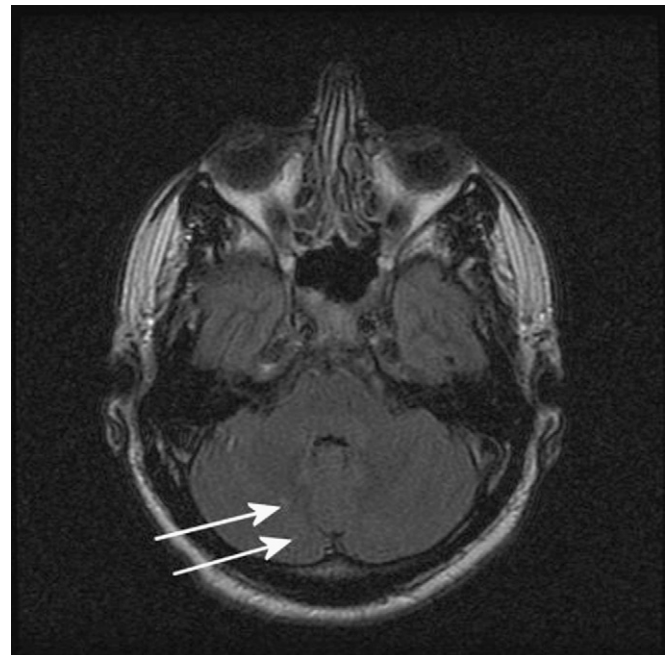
FLAIR MRI image depicting similar punctate lesions in the right cerebellum (solid arrows).
